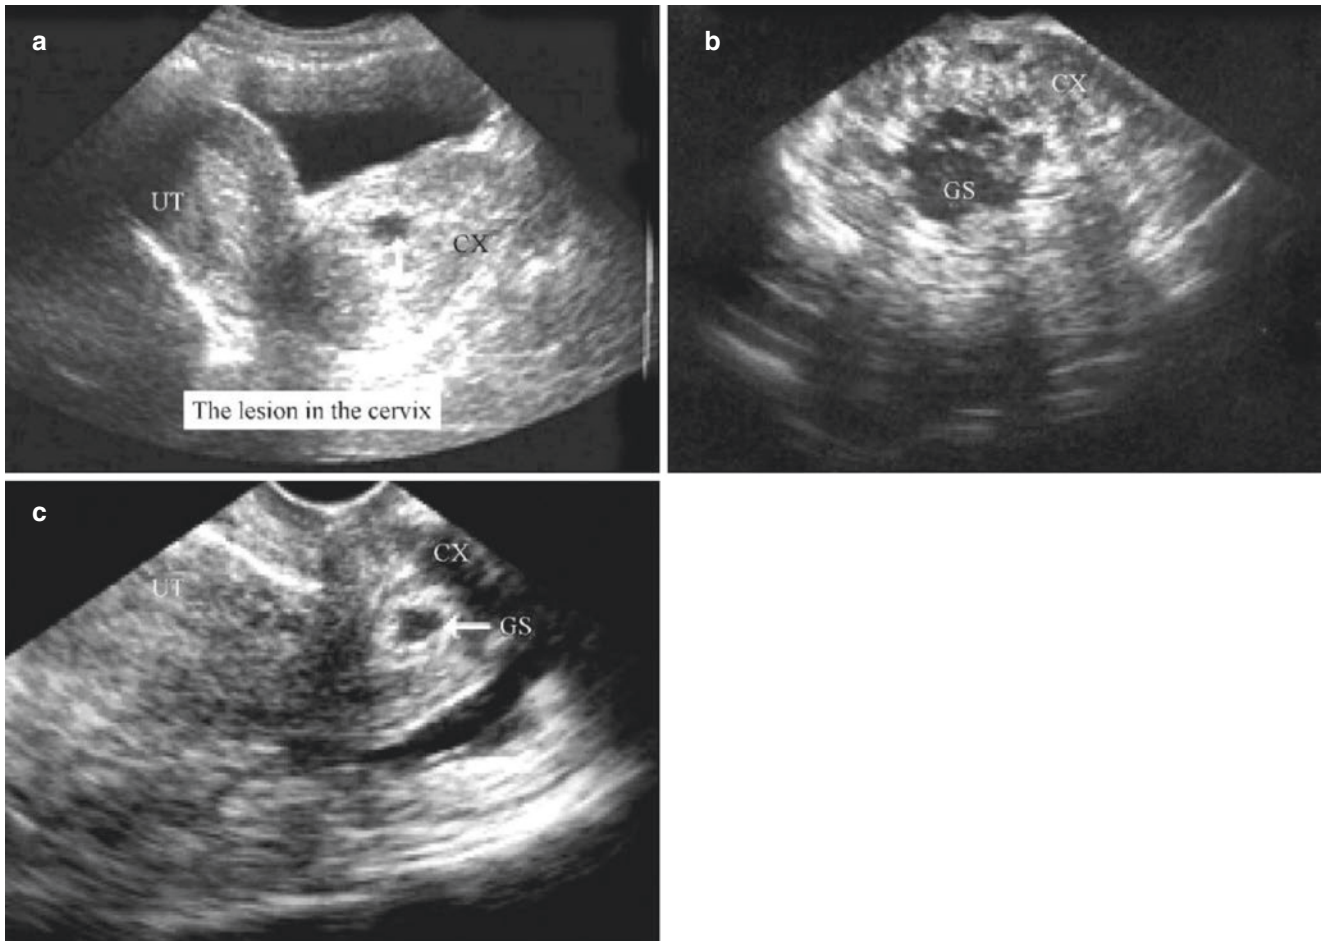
Cervical ectopic pregnancy. (a). At 46 days of amenorrhea, ultrasound shows no pregnancy tissue in the uterine cavity, and the cervix is “barrel-shaped” enlarged with a gestational sac-like echo (0.8 cm in diameter), which is diagnosed as cervical ectopic pregnancy. (b). After 49 days of amenorrhea, there is no pregnancy in the uterine cavity. On the anterior wall of the lower uterine segment, heterogeneous hyper-echoic mass with a diameter of about 5.0 cm is found, which protruding
